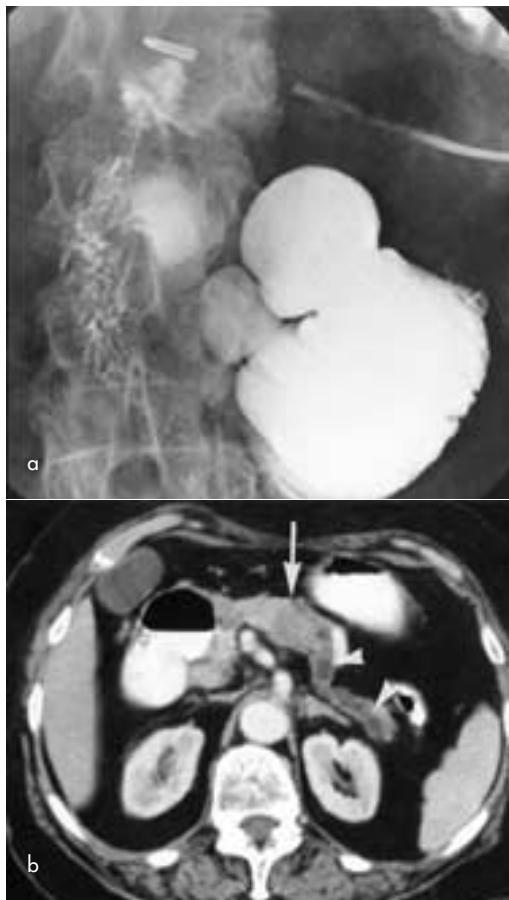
Carcinoma of the pancreas. a. Barium examination shows complete obstruction with some dilatation of the duodenum just proximal to the duodenojejunal flexure (ligament of Treitz). A number of duodenal diverticula are also seen. b. Computed tomography confirms the presence of a pancreatic carcinoma (arrow) in the body of the pancreas. Note the marked dilatation of the pancreatic duct in the tail of the pancreas (arrowheads).
